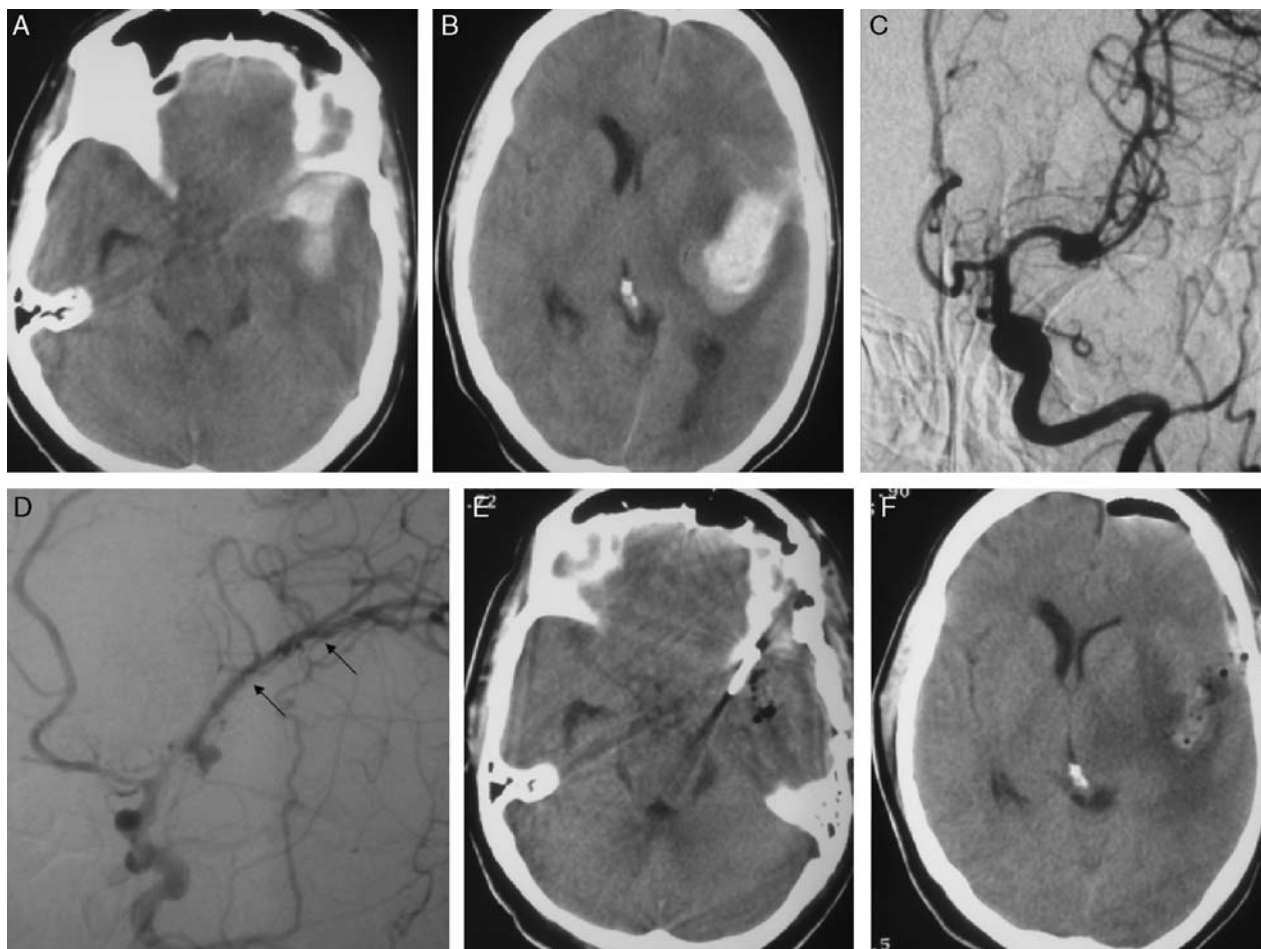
This 34-year-old female patient presented with a sudden onset headache accompanied by speech difficulties and right hemiparesis. A and B, A CT scan showed a typical left temporal lobe ICH with a midline shift and a subarachnoid hemorrhage. C and D, Angiography revealed a left MCA bifurcation aneurysm with elevation of the MCA by the ICH. E and F, Postoperative CT scan shows evacuation of the ICH and clips. CT indicates computed tomography; ICH, intracerebral hematoma; MCA, middle cerebral artery.
